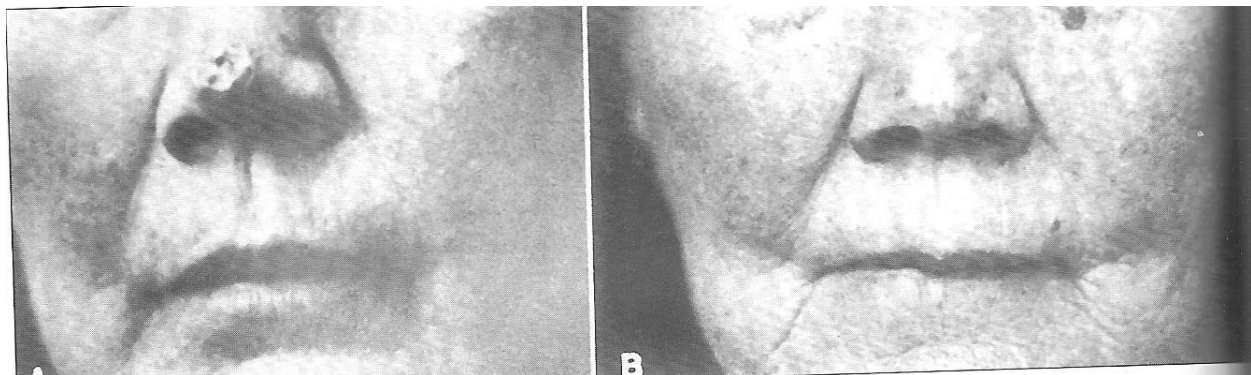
The first cancer cure with x-rays
